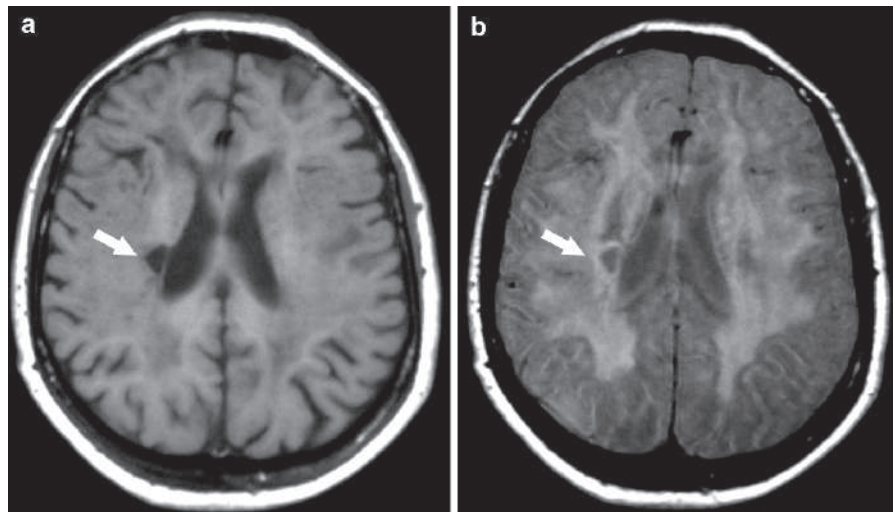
Axial T1W (a) and FLAIR (b) brain MRI of another patient with CADASIL shows bilateral diffuse white matter lesions (leukoencephalopathy) with dilated right Virchow–Robin space (arrowhead)
